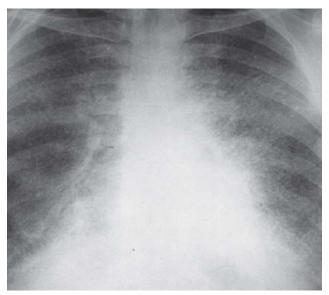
Chest radiograph (postero-anterior view) of first case showing bilateral diffuse opacities at the lung bases obscuring the cardiac Silhouette.
